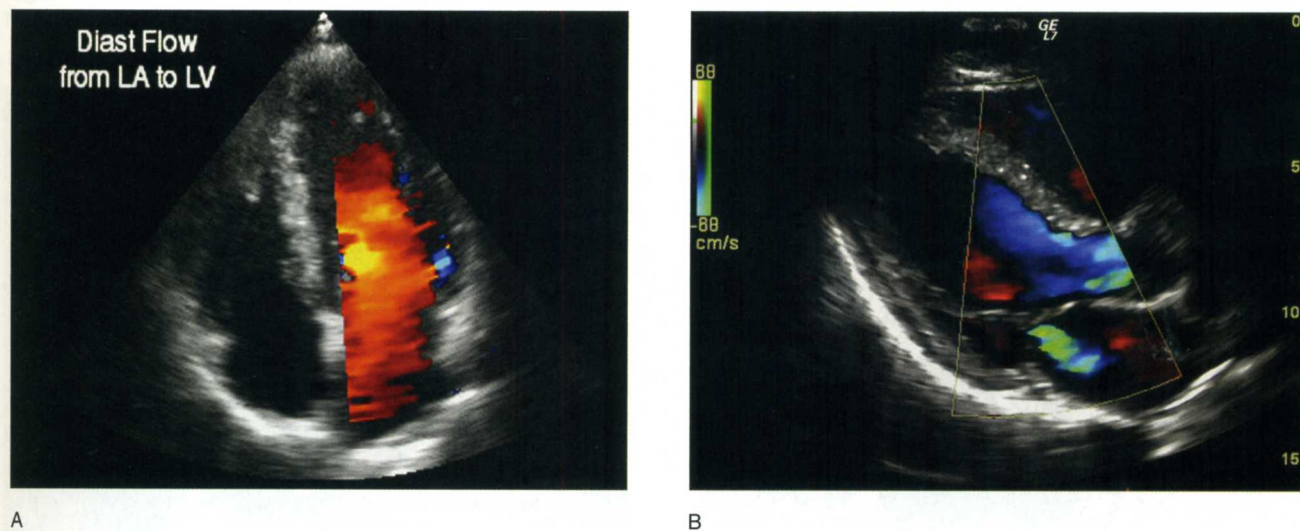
Color Doppler flow through left ventricle, apical four-chamber view - conventional color key (A). Flow during diastole is toward the transducer and is coded red in this example. Color Doppler flow on parasternal long-axis view - variance mode color key (B). Shades of green have been added to indicate areas of turbulence. (Courtesy of GE Medical for (B))
